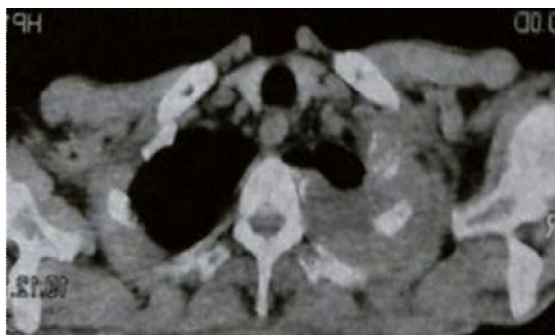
Axial CT image shows a homogenous lung mass in the right apical region destroyed the adjacent ribs
